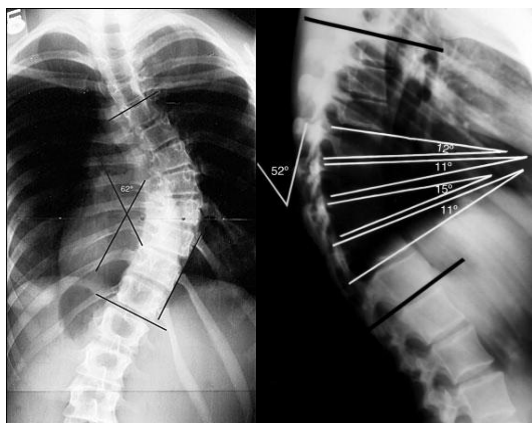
Measuring Cobb-angles a.) from the frontal X-Ray picture (in case of scoliosis) b.) from the sagittal X-ray picture (in case of Scheuermann disease) [10]
